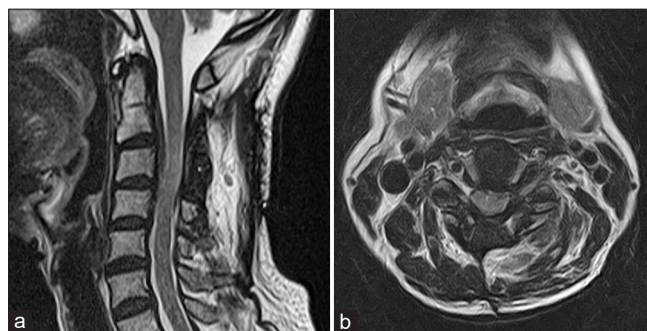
(a) Sagittal T2-weighted magnetic resonance imaging (MRI) showing an isointense lesion extending from C2 to C4. (b) T1-weighted MRI revealed an epidural lesion compressing the cervical spinal cord from the left to the right. (c) T1-weighted MRI with contrast enhancement demonstrating uniform contrast uptake by the lesion.
